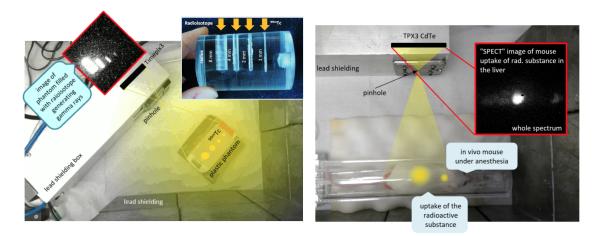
SPECT measurement experimental setup
